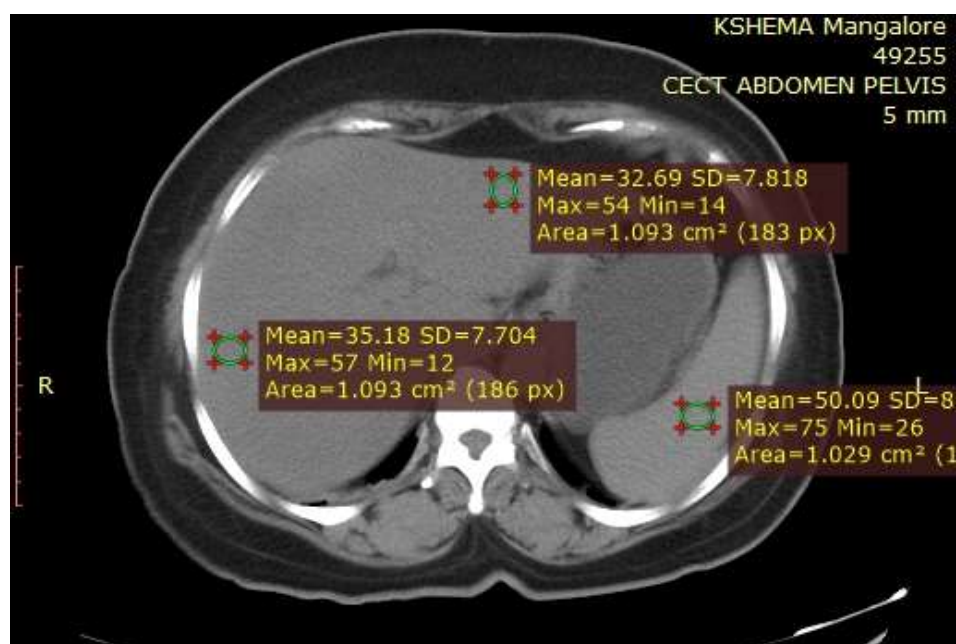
Unenhanced CT scan shows fatty infiltration of liver with an attenuation value of right lobe of liver 35HU and left lobe of liver 32HU and attenuation of spleen as 50HU indicating grade II fatty liver
